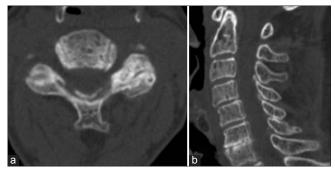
CT scans (a and b) obtained just before the operation showed an amorphous, expansible, multilobulated and calcified mass in the posterior element of C3 and C4, with encroachment into the spinal canal
